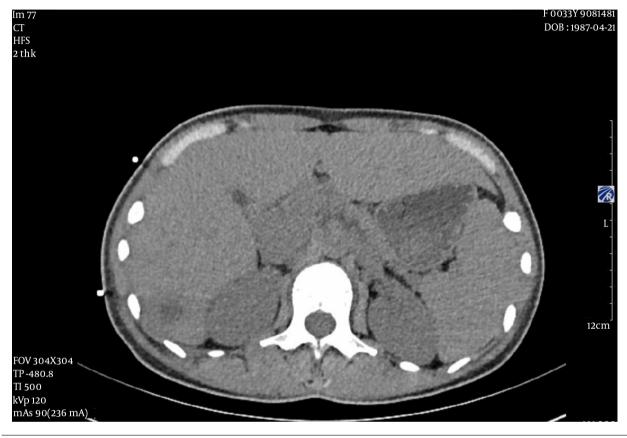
Abdominal CT indicating significantly reduced lesions
